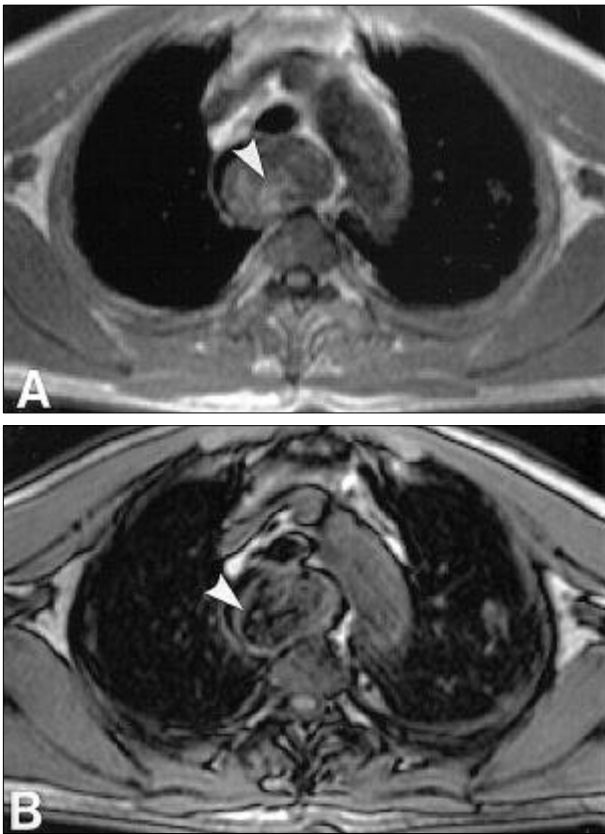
(A) In-phase T1-weighted MR image showing an inhomogeneous low signal intensity mass with internal high signal intensity foci (arrowhead) in the dilated esophagus. (B) Out-of-phase T1-weighted MR images showing decreased signal intensity (arrowhead) of the high signal intensity foci within the esophageal mass, indicating a fat containing mass.
